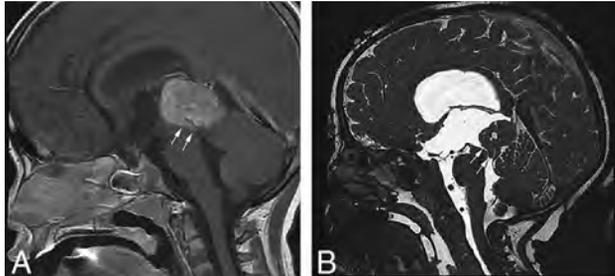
Sagittal T1-weighted postcontrast (A) and sagittal high-resolution balanced steady-state gradient-echo (B) images from 2 different patients with molecularly proved pineoblastomas demonstrating a tail-like aqueductal extension (white arrows).
